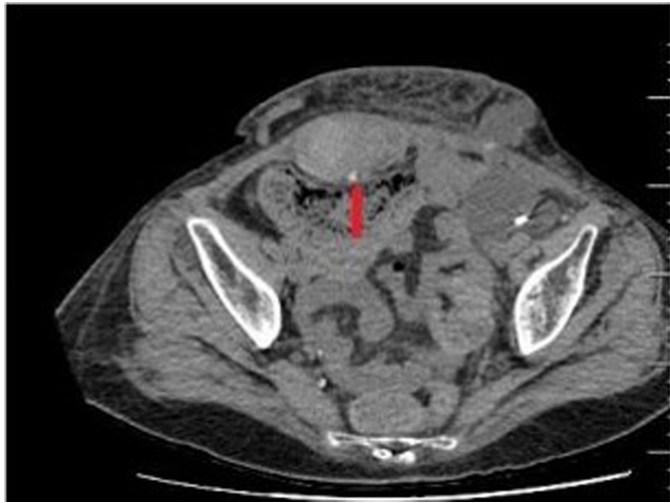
CT image of Case 2.
